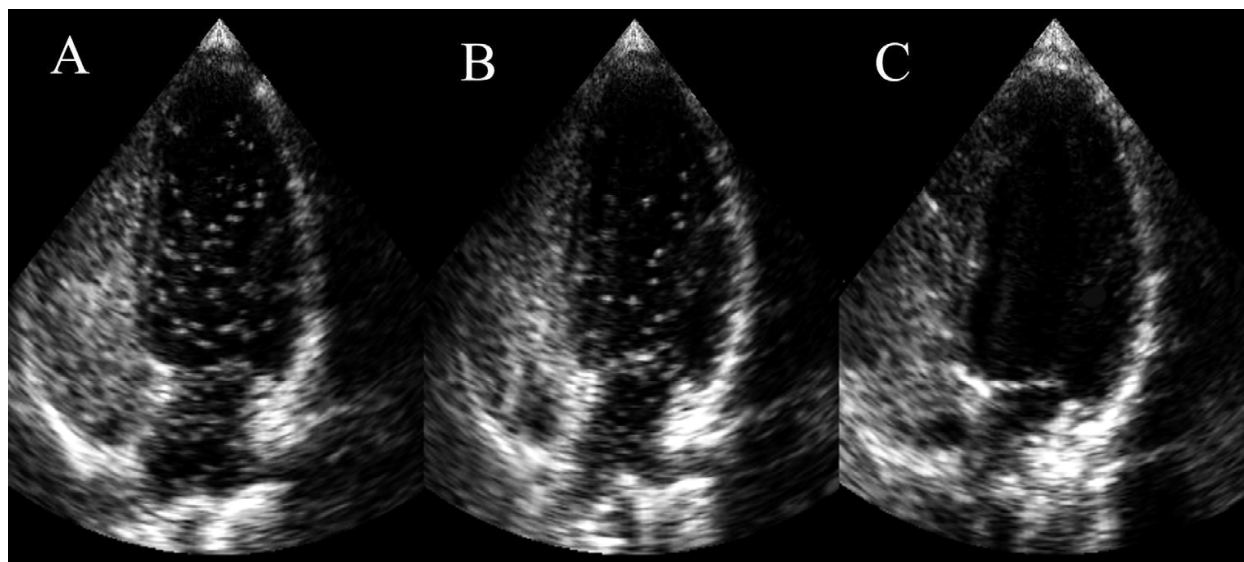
Echocardiograms during exercise in hypoxia (A), normoxia (B) and hyperoxia (C). Note left side contrast is greatest in hypoxia (A) but is absent during in hyperoxia (C).
